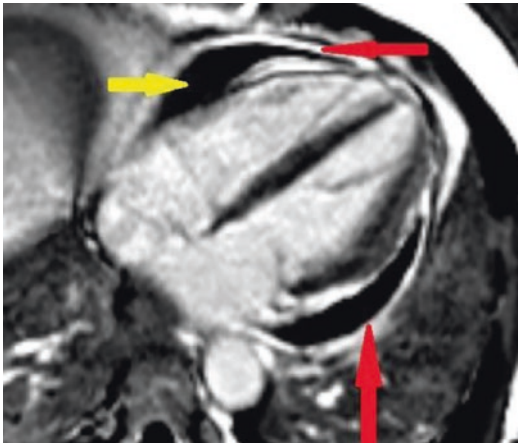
MRI of pericarditis and effusion. Yellow arrows indicate pericardial effusion. Red arrows are gadolinium enhancement of inflamed pericardium
